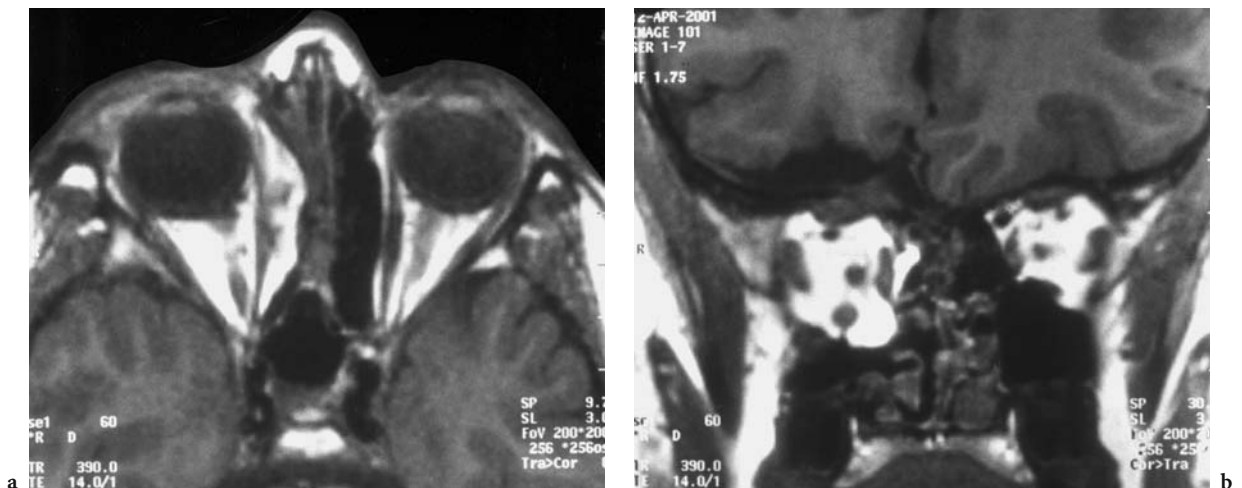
A 10-year-old boy with enophthalmos of the right eye, which developed several months after severe facial trauma. Diagnosis: state after orbital floor fracture with posttraumatic enophthalmos. T1-weighted native MRI: a Axial view with slight enophthalmos of the right globe and fat prolapse into the right ethmoidal cell, representing a posttraumatic residual. b Coronal view, demonstrating additional fat prolapsing into the maxillary sinus as a result of orbital floor dehiscence
